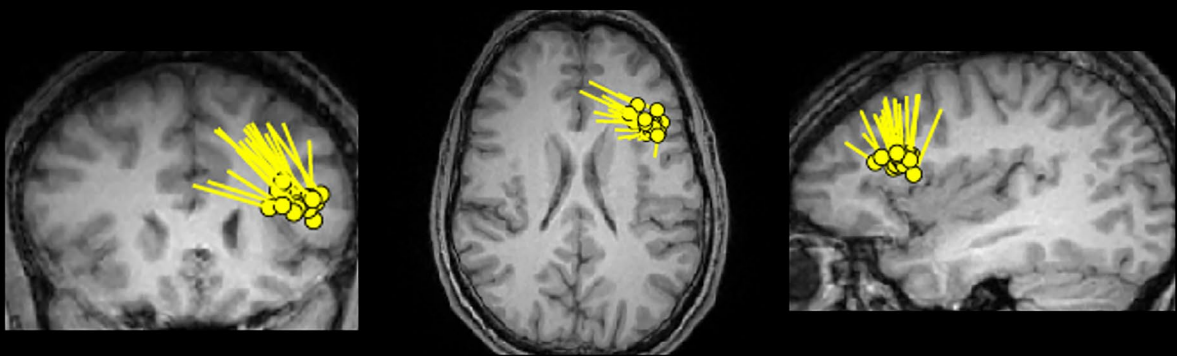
Case 2: Presurgical multimodal data from the initial evaluation. (A) 3T T1w MRI in coronal, axial, and sagittal planes, initially reported as nonlesional. (B) 3T FLAIR in two coronal slices and one coronal slice near the subtle abnormality later identified. In retrospect, some features of FCD are discernible on these slices; however, they were too subtle to identify prospectively without post-processing assistance. (C) FDG-PET showing hypometabolism in the left inferior frontal gyrus. Arrows point to the hypometabolic regions pertinent to the subtle abnormality later identified. (D) Source localization of interictal dipoles on magnetoencephalography (MEG).
